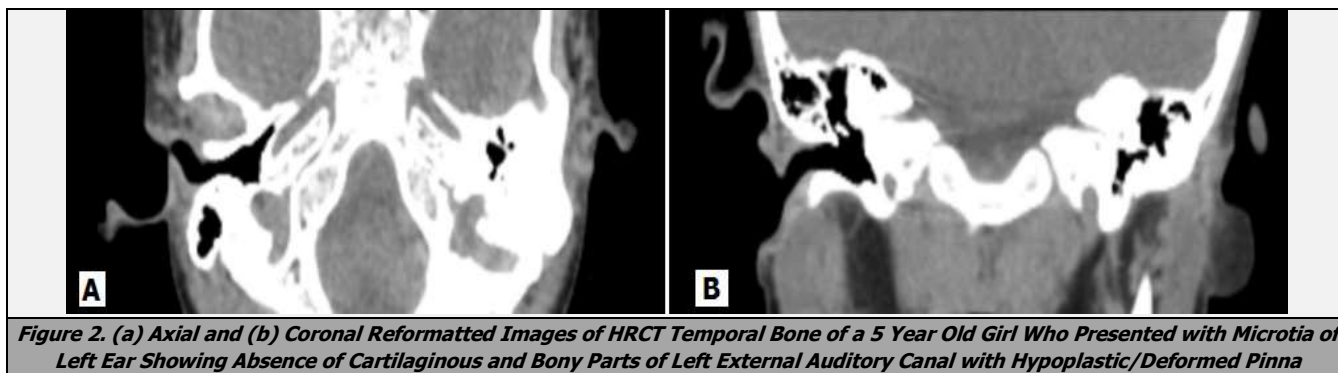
(a) Axial and (b) Coronal Reformatted Images of HRCT Temporal Bone of a 5 Year Old Girl Who Presented with Microtia of Left Ear Showing Absence of Cartilaginous and Bony Parts of Left External Auditory Canal with Hypoplastic/Deformed Pinna
